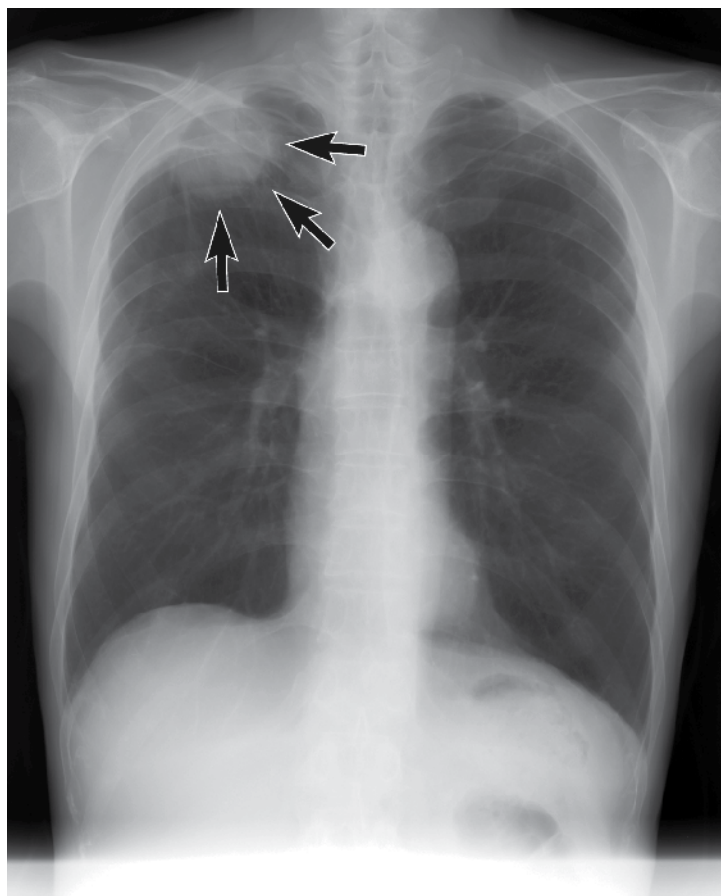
A chest radiography demonstrates a large mass adjacent to the chest wall in the right apical area.
